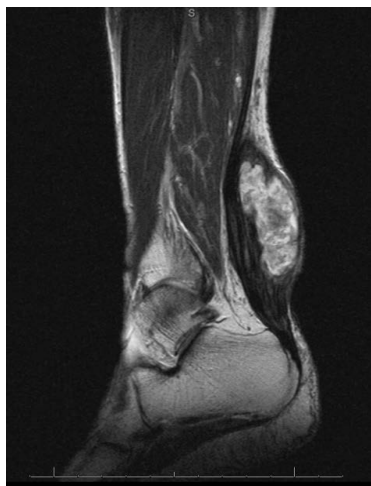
Sagittal MRI view of the xanthoma in the right Achilles tendon.
